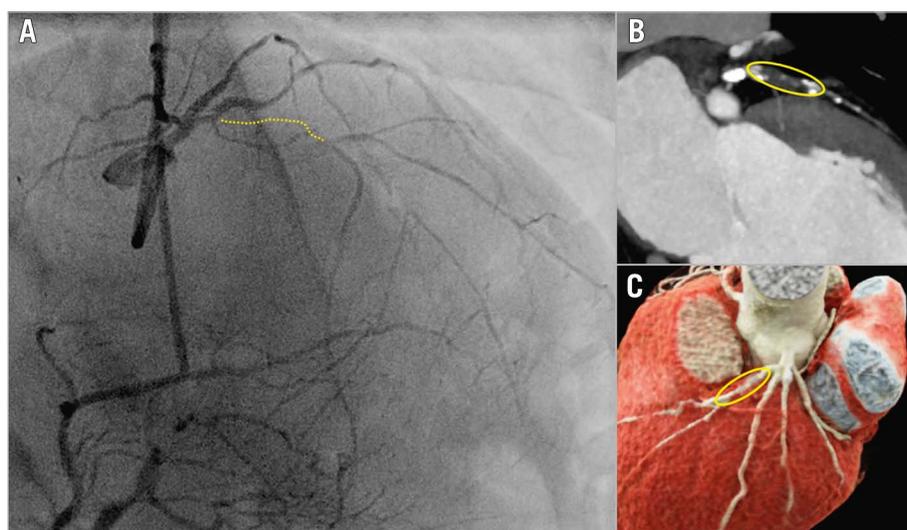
Role of dual injection in antegrade CTO PCI. A) Dual injection is fundamental to highlight the length (>20 mm) of a CTO of the mid LAD (yellow dotted line), in order to visualise not only the proximal, but also the distal coronary bed (distal LAD in this case retrogradely filled from RCA-septal collaterals). B & C) MSCT showing the proximally occluded LAD segment (indicated in a yellow circle). Note the presence of calcium at the proximal and distal end of the occlusion, while the midsegment appears spared. The preintervention MSCT allows the operator to anticipate potential difficulties. In this case, it might be expected that appropriate changes in guidewire stiffness (step-up/step-down) through the microcatheter are required. CTO: chronic total occlusion; LAD: left anterior descending artery; MSCT: multislice computed tomography; PCI: percutaneous coronary intervention; RCA: right coronary artery
